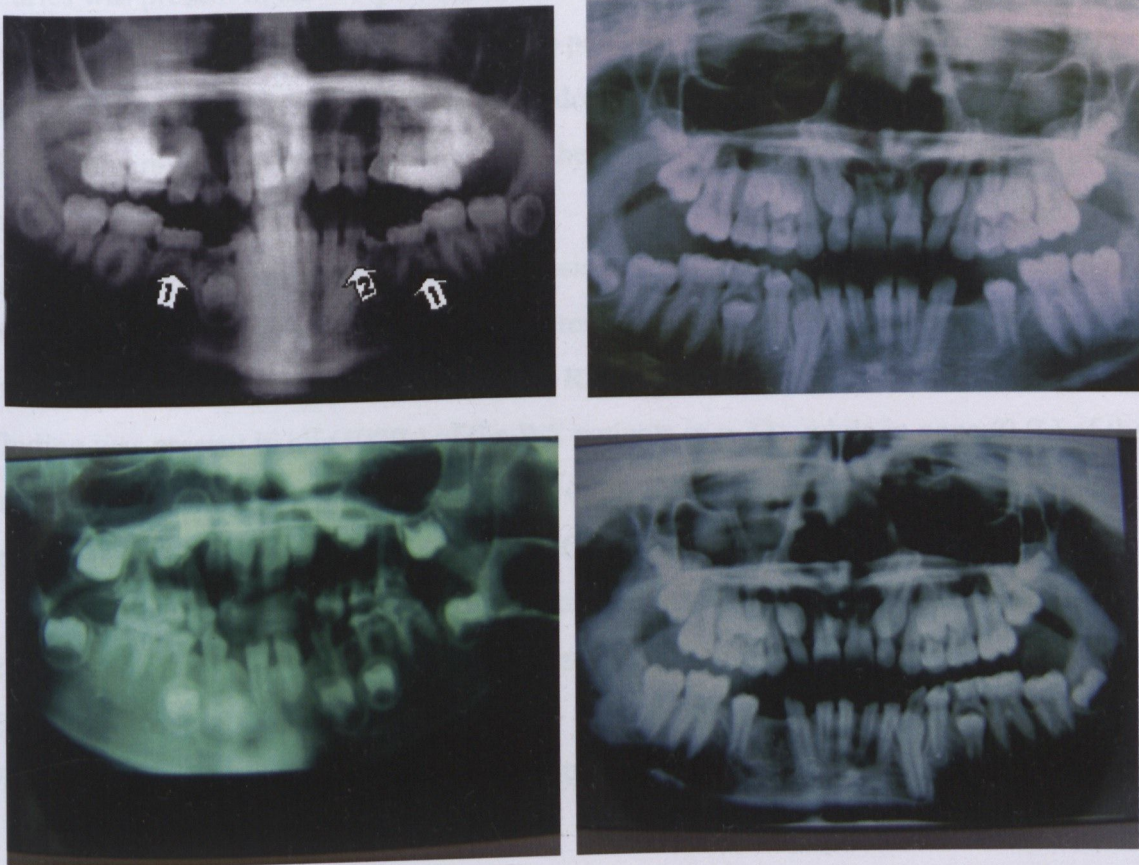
Orthopantomogram tomographic radiography of a typical Williams syndrome patients showing aplasia and tooth resorption anomaly, with fan shaped positioning of the front teeth.
